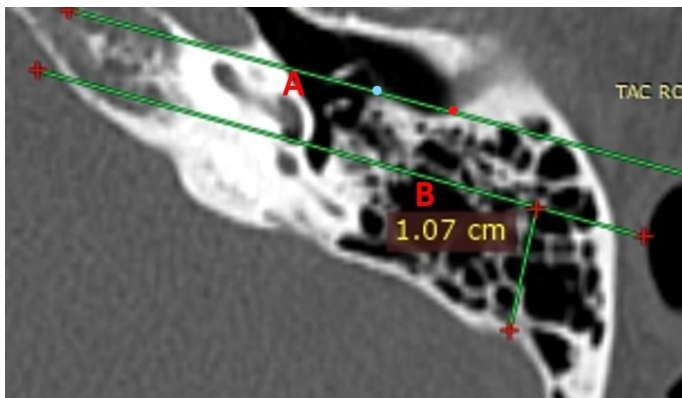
Left axial CT showing our proposed method for sigmoid sinus position. A line of the plane of the external auditory canal, blue dot: tympanic annulus, red dot: bony cartilaginous junction. B line parallel to A passing through anteromedial surface of the mastoid FN
